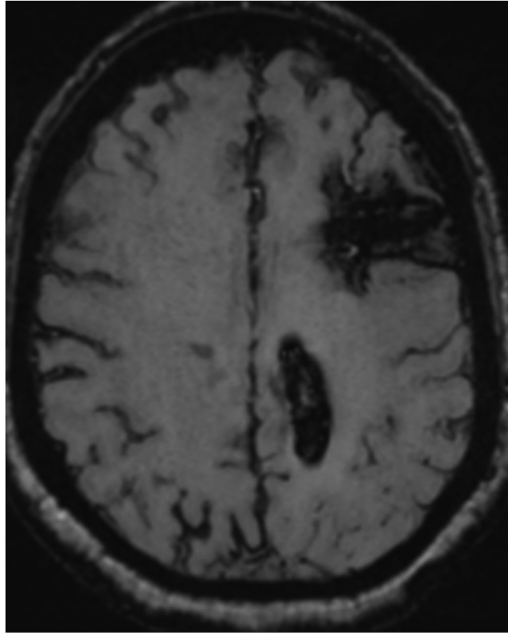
Axial MRI of the brain—susceptibility weighted imaging—of a 63-year-old woman with multiple lobar hemorrhages, with probable diagnosis of CAA.
